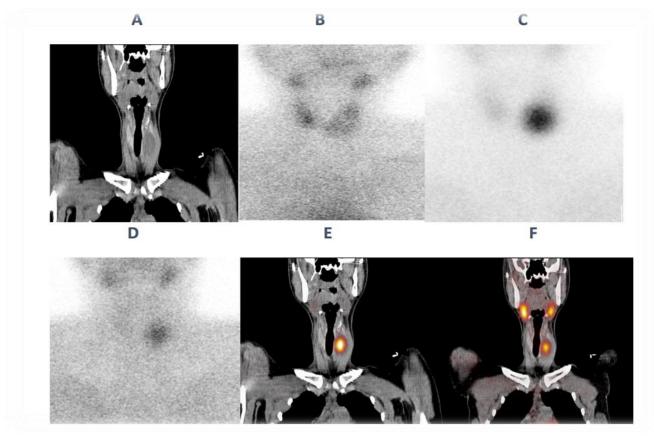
A 26-years old female patient with a hypodense left thyroid lobe nodule on CT image (A), (B)^{99m}Tc-pertechnetate thyroid scintigraphy demonstrating an isofunctioning left thyroid lobe nodule.^{99m}Tc-MIBI early (C), late (D) planar images, early (E) and late (F) SPECT/CT images: the tracer washout pattern is consistent with decreased uptake. Final pathology revealed a follicular adenoma.
